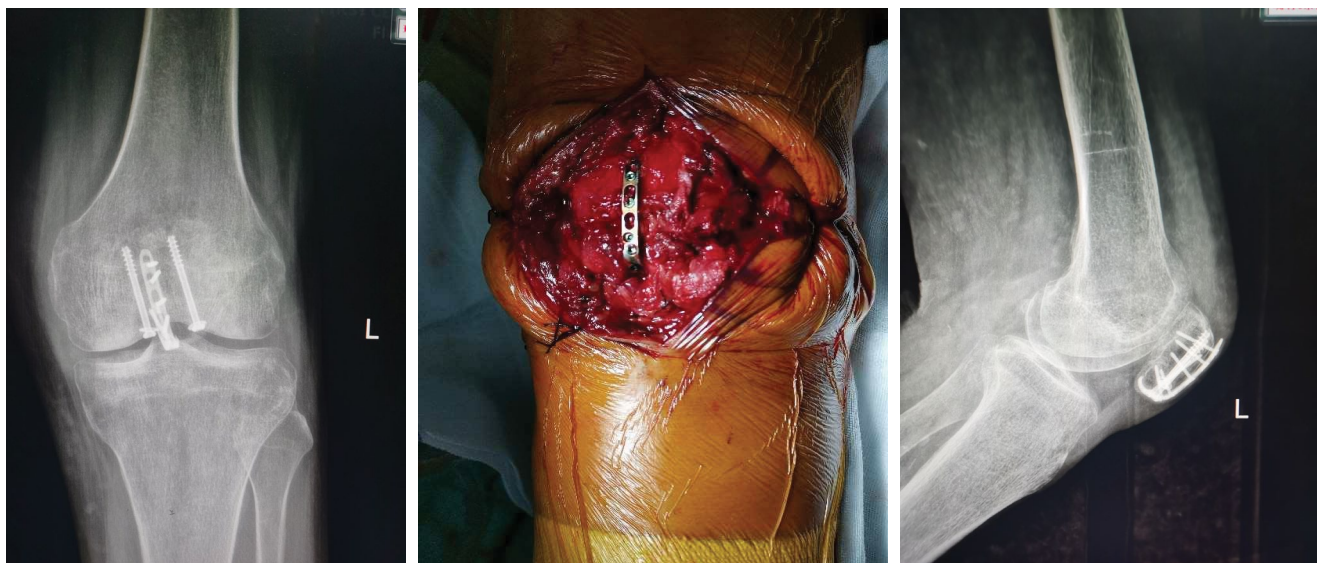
Intraoperative radiograph of miniature plate internal fixation.
